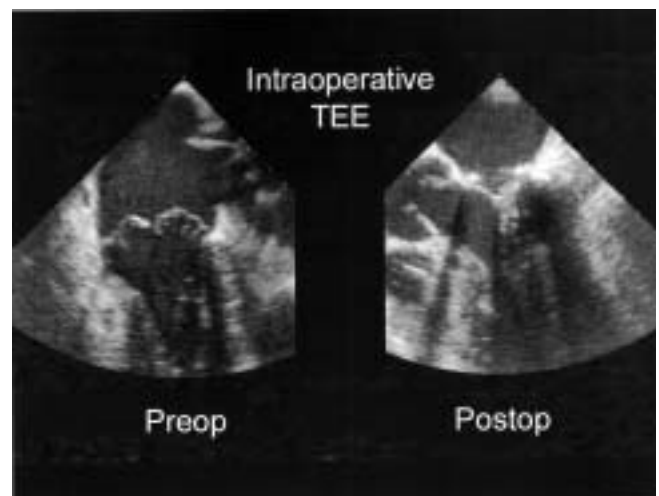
Pre- and postoperative transesophageal echocardiograms of a patient with Barlow's syndrome. Note the good postoperative leaflet position, and the large surface area of leaflet coaptation. The valve was completely competent on color flow mapping.
